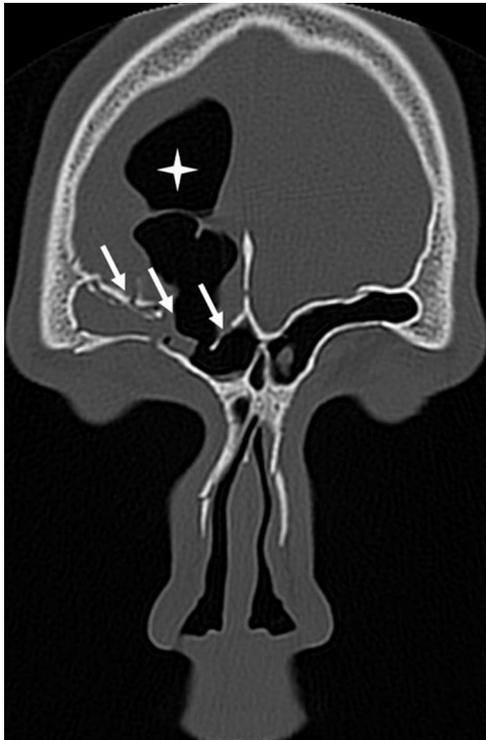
Forty-two-year-old man with watery discharge from right nostril after a road traffic accident. Coronal CT brain in bone window shows fracture involving anteroinferior and posterosuperior walls of frontal sinus (arrows) with pneumocephalus in right frontal region, continuous with air in right frontal sinus (star).
